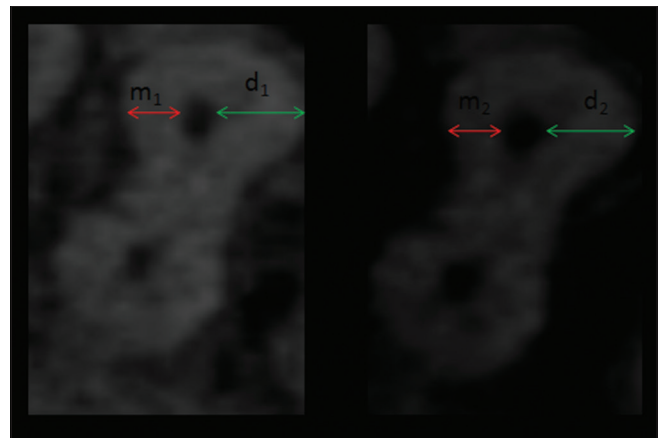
Pre- and post-instrumentation cone-beam computed tomography images
